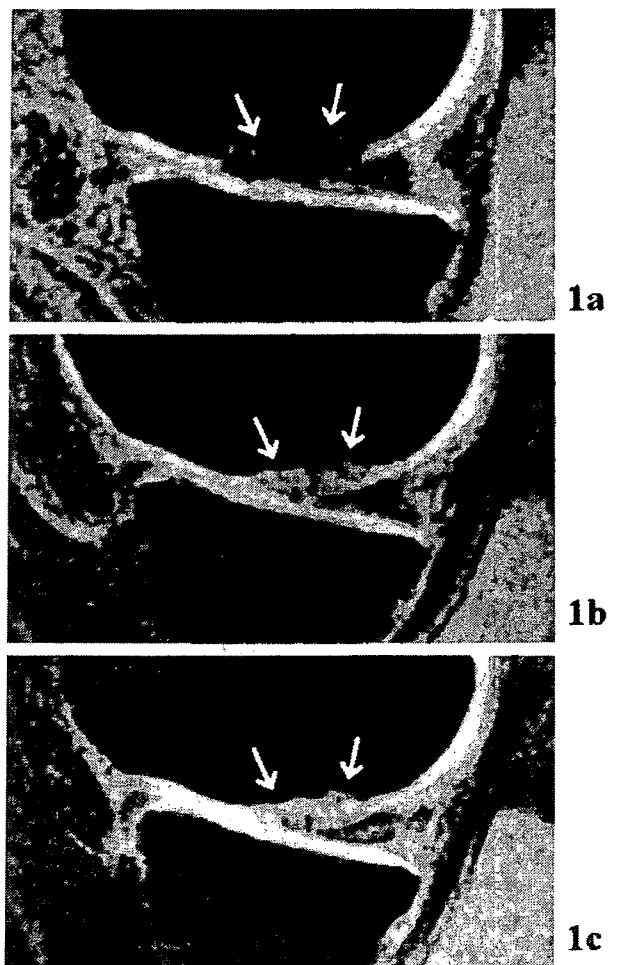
The time course change of signal intensity in three-dimensional spoiled gradient-recalled (3D-SPGR) magnetic resonance (MR) images of a typical case. The signal intensity of reparative cartilage (arrows) appeared low immediately after autologous chondrocytes implantation (ACI), but it increased and approached that of normal cartilage with time. (a) MR image immediately after ACI, (b) MR image 3 months after ACI, (c) MR image 12 months after ACI.
